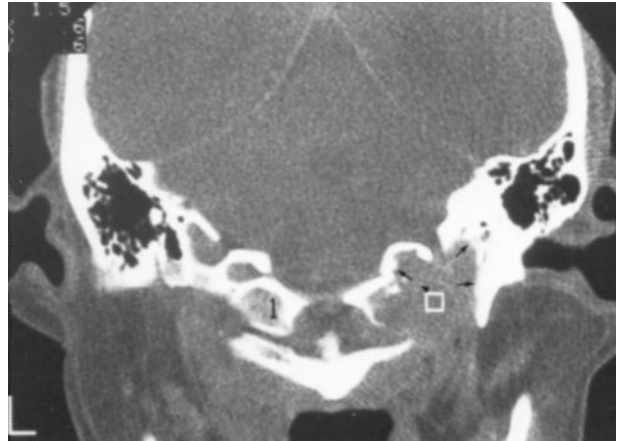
Liposarcoma of the base of the skull. Contrast-enhanced coronal computed tomographic scan showing extensive bone destruction of the right jugular fossa and occipital condyle (arrows). Note erosion of the right occipital condyle as compared with the left one (1).
